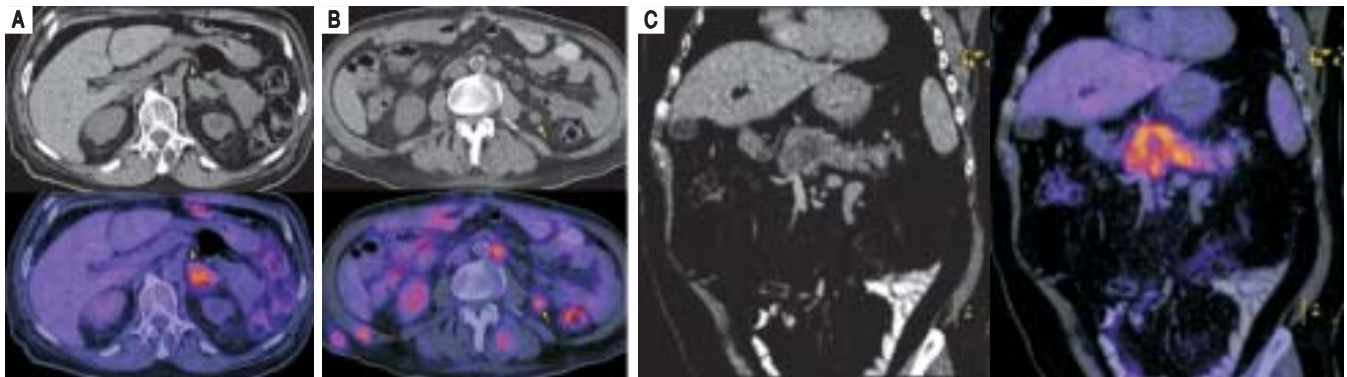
^{18}F -FDG PET-CT. A-B. 70 y.o. male with metastatic urinary bladder cancer: high glycolytic uptake in an increased and nodular left adrenal gland, as well as in some lymphadenopathies in the retroperitoneal space, mesentery, muscular and subcutaneous tissue. C. 63 y.o. male with pancreatic adenocarcinoma: Abnormal glycolytic activity in an irregular mass on the head of the pancreas, associated with fat stranding and lymphadenopathy.
